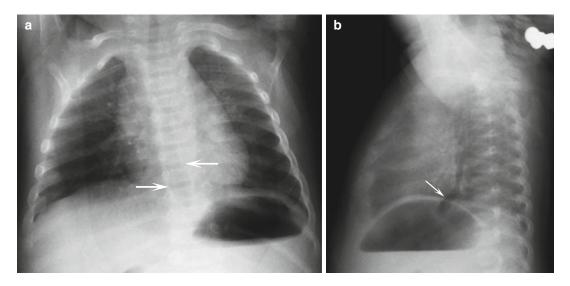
(a, b) Air outlining a normal esophagus. (a) AP and (b) lateral chest radiographs of a crying infant with an air-filled esophagus (*arrows*) secondary to aerophagia
